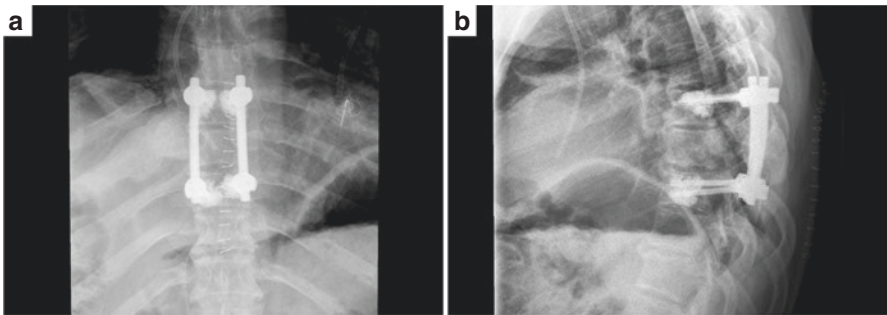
Postoperative x-rays demonstrating T7–9 posterior instrumented fusion with cement-augmented pedicle screws. (a) AP. (b) Lateral
